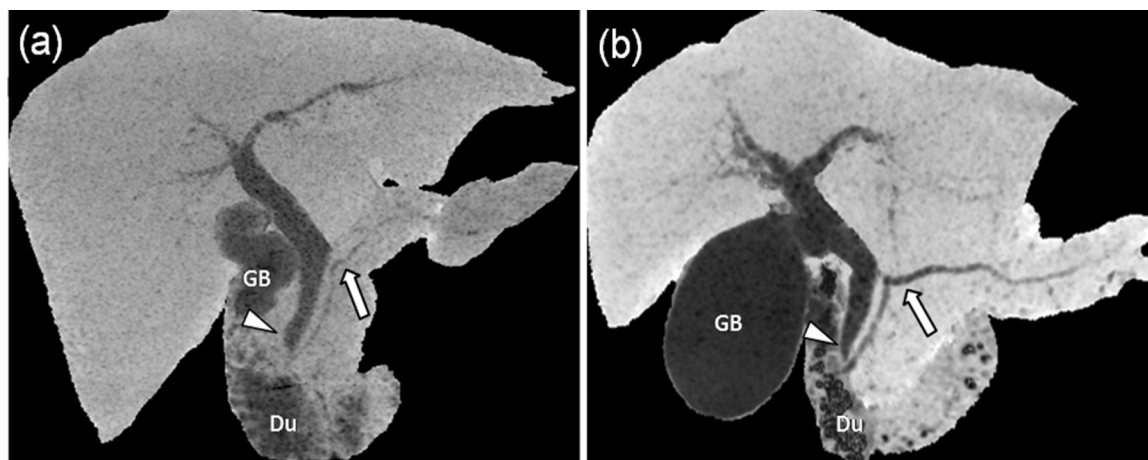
Slightly biliary dilatation secondary to benign ampullary stenoses confirmed by endoscopy. 3D nCTCP with MinIP images from SECT (A) in a 67-year-old female with a BMI of 17.48 and DECT (B) in an 85-year-old female with a BMI of 18.03. Subjective image quality evaluation on DECT demonstrates lower image noise (grade of 5 vs 4), sharper extrahepatic bile duct (arrowheads) and pancreatic duct (arrows) (grade of 5 vs 4) as well as better overall image quality than on SECT (grade of 5 vs 4). Both CT sets show a typically benign sign—gradual tapering of the common bile duct (arrowheads). Du, duodenum; GB, gallbladder.
